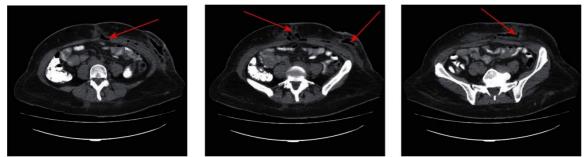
A 44-year old female patient M. CT-signs of infiltrative and inflammatory changes in the soft tissues of the anterior abdominal wall in the anterior-left regions with the formation of an undrained liquid area
